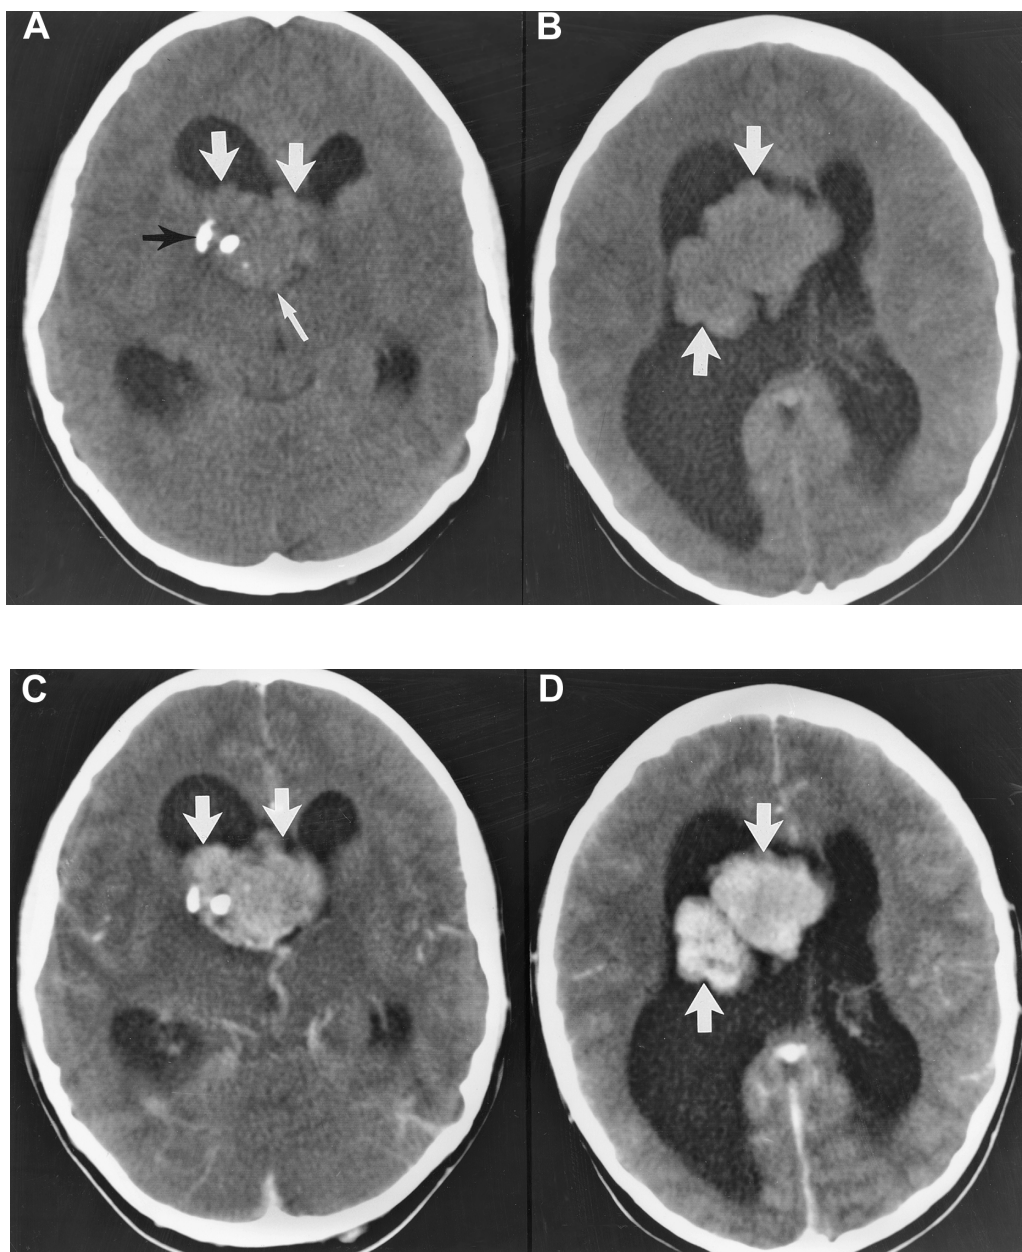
An 11-year-old boy with tuberous sclerosis and with intraventricular masses (subependymal giant cell astrocytoma). (A,B) Non-contrast CT of the brain. Dense mass with calcifications (black arrow in A) is shown occupying the frontal horns and body of lateral ventricles (arrows) extending down to the foramen of Monro region (small arrow in A). (C,D) Intravenous contrast CT of the brain. Enhancing features of the tumor (arrows) are revealed in post-contrast images.
